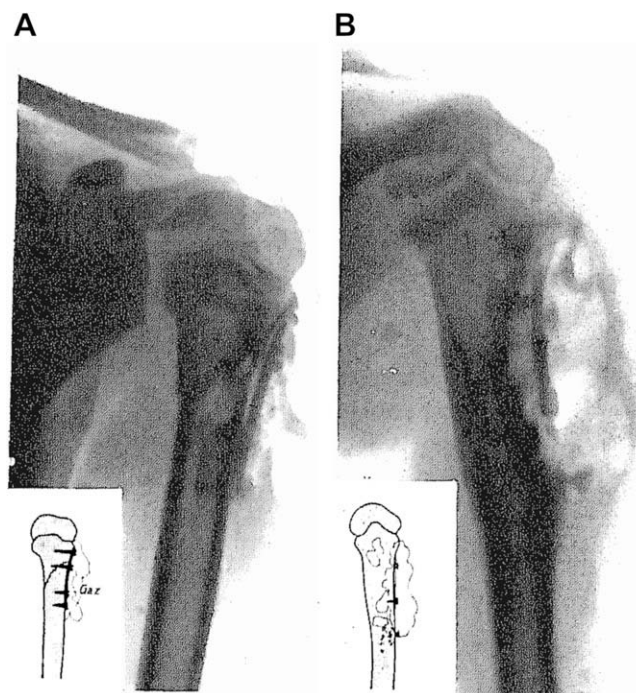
Verbrugge used a magnesium plate and screws to stabilize a diaphyseal humerus fracture in an 8 year old child. (A) Postoperative X-rays demonstrating already formed gas cavities; (B) the magnesium plate was mainly corroded at 3 weeks after the operation [9].
